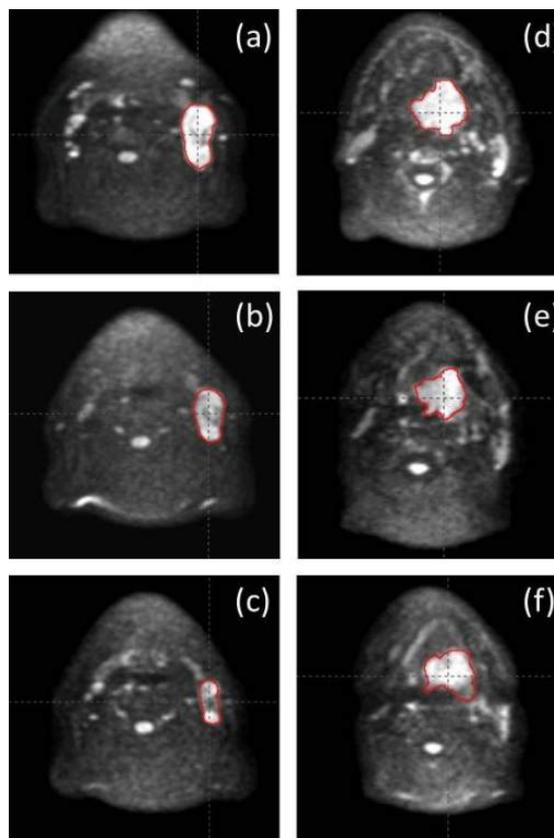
DWI ROI delineation for PT2: (a)-(c) and PT8: (d)-(f) pre- (upper), 2.5 weeks intra- (middle) and 5 weeks intra-treatment (lower).
